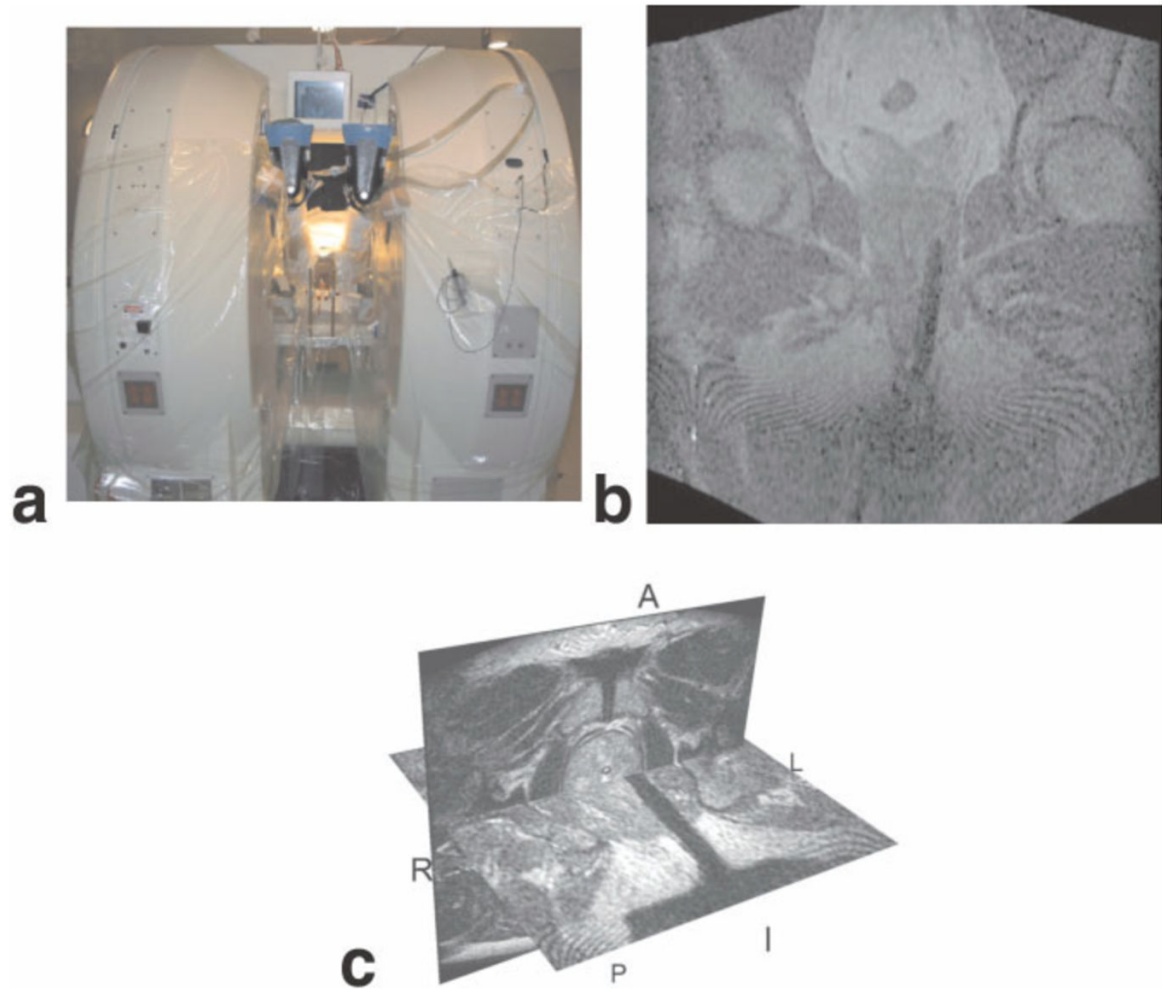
MR-guided prostate biopsy. The MRT Signa/SP system (a) setup for MRI-guided prostate biopsy. Coronal FGR image (b) showing biopsy needle inserted on the left side. 3D Slicer (c) showing the combination of the needle on FGR image with the T2-weighted image of the prostate.
